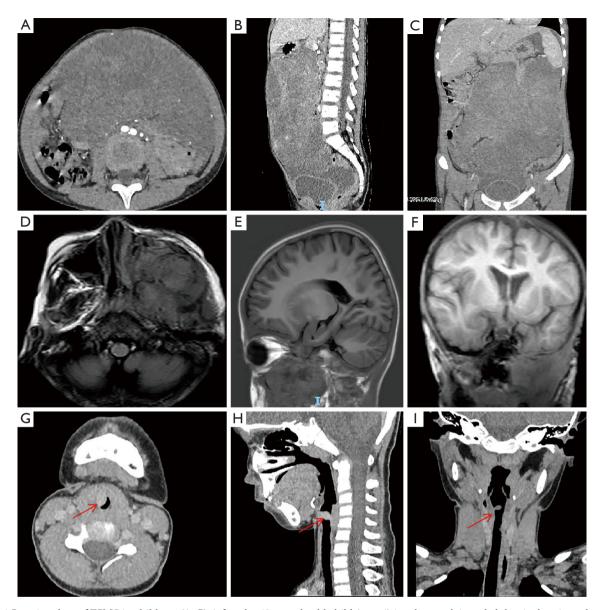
Imaging data of EIMS in children. (A-C) A female, 68-month-old child (case 4) in whom pelvic and abdominal cavity enhancement CT suggested a giant pelvic and abdominal occupancy with inhomogeneous enhancement, with a maximum diameter of 19.30 cm. (D-F) A male, 75-month-old child (case 5) in whom maxillofacial MR suggested a giant left maxillofacial occupancy with a maximum meridian of 10.80 cm. (G-I) A female, 66-month-old child (case 7) in whom enhanced CT suggested a larvngeal occupancy with a maximum meridian of 0.65 cm (arrows). EIMS, epithelioid inflammatory myofibroblast sarcoma; CT, computed tomography; MR, magnetic resonance.
